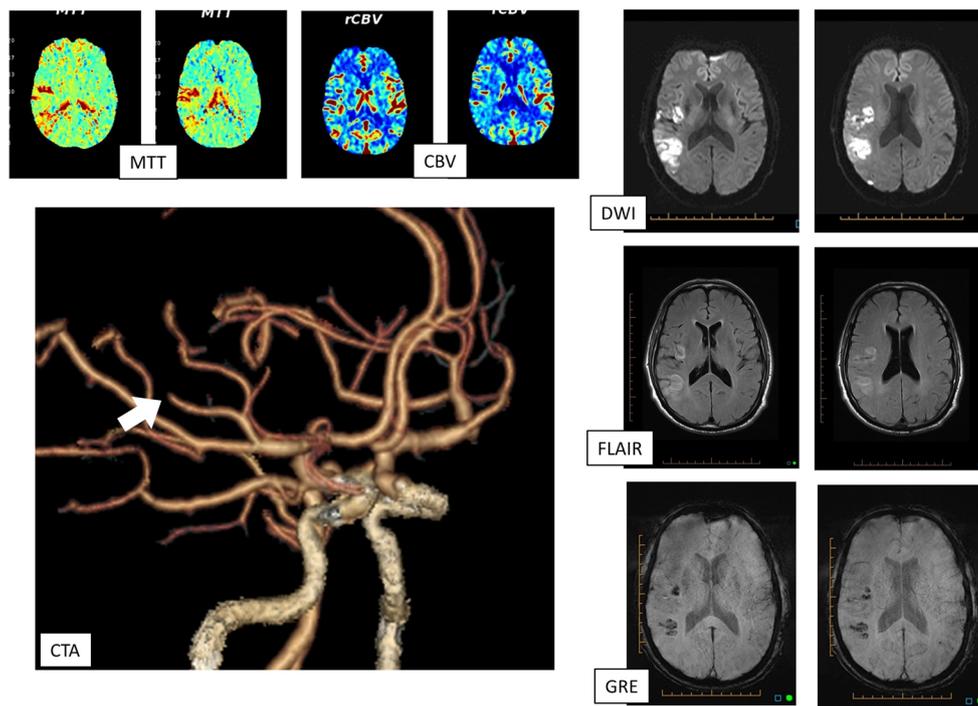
Imaging studies of a patient with a cortical cardiogenic embolism, treated with intravenous thrombolysis. Upon admission, the CTP scan demonstrates the ischemic penumbra (MTT) in the right hemisphere, with minimal evidence of an ischemic core (CBV). The admission CTA demonstrates the occluded cortical branch (arrow). Approximately 24 h following the administration of intravenous alteplase, the MRI shows
